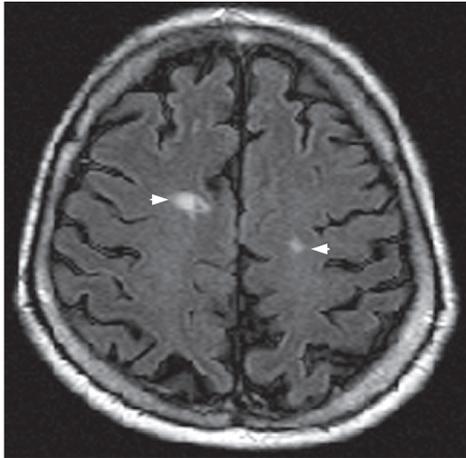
Bilateral small centrum ovale infarcts on an MRI scan (arrowheads).
